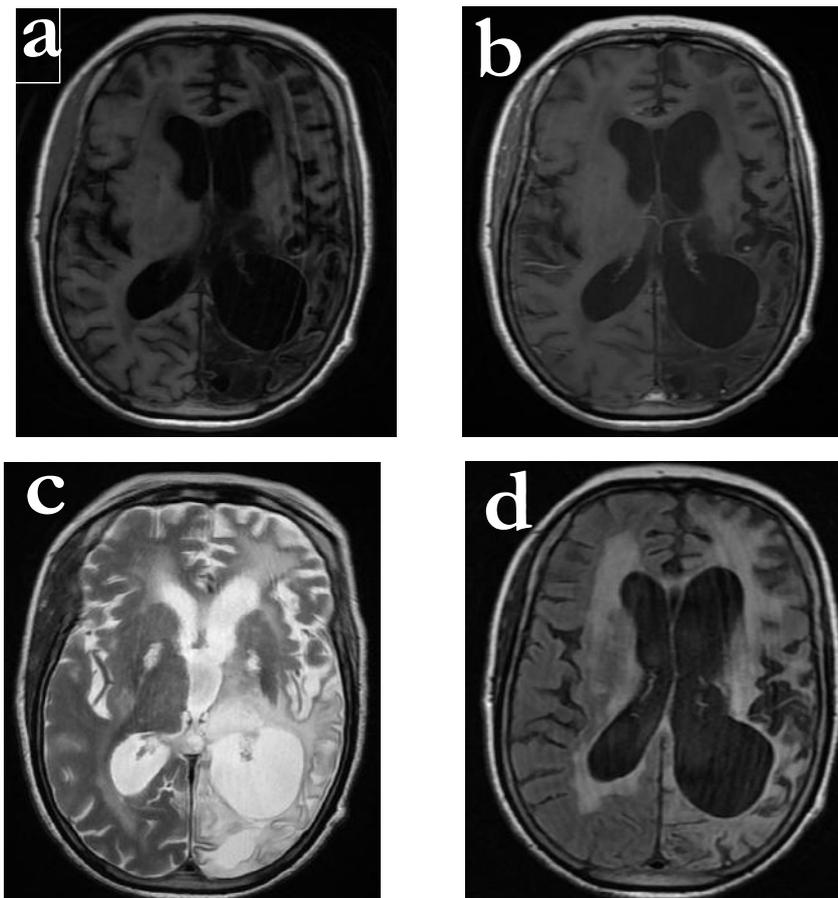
(a-d): Axial T1W, T1W+c, T2W and FLAIR brain MRI showing severe left unihemispheric cerebral atrophy involving the ipsilateral head of caudate nucleus, thalamus, and cerebral peduncle, with associated ex vacuo dilatation of all components of the ipsilateral lateral ventricle and the third ventricle. No significant area of contrast enhancement.
